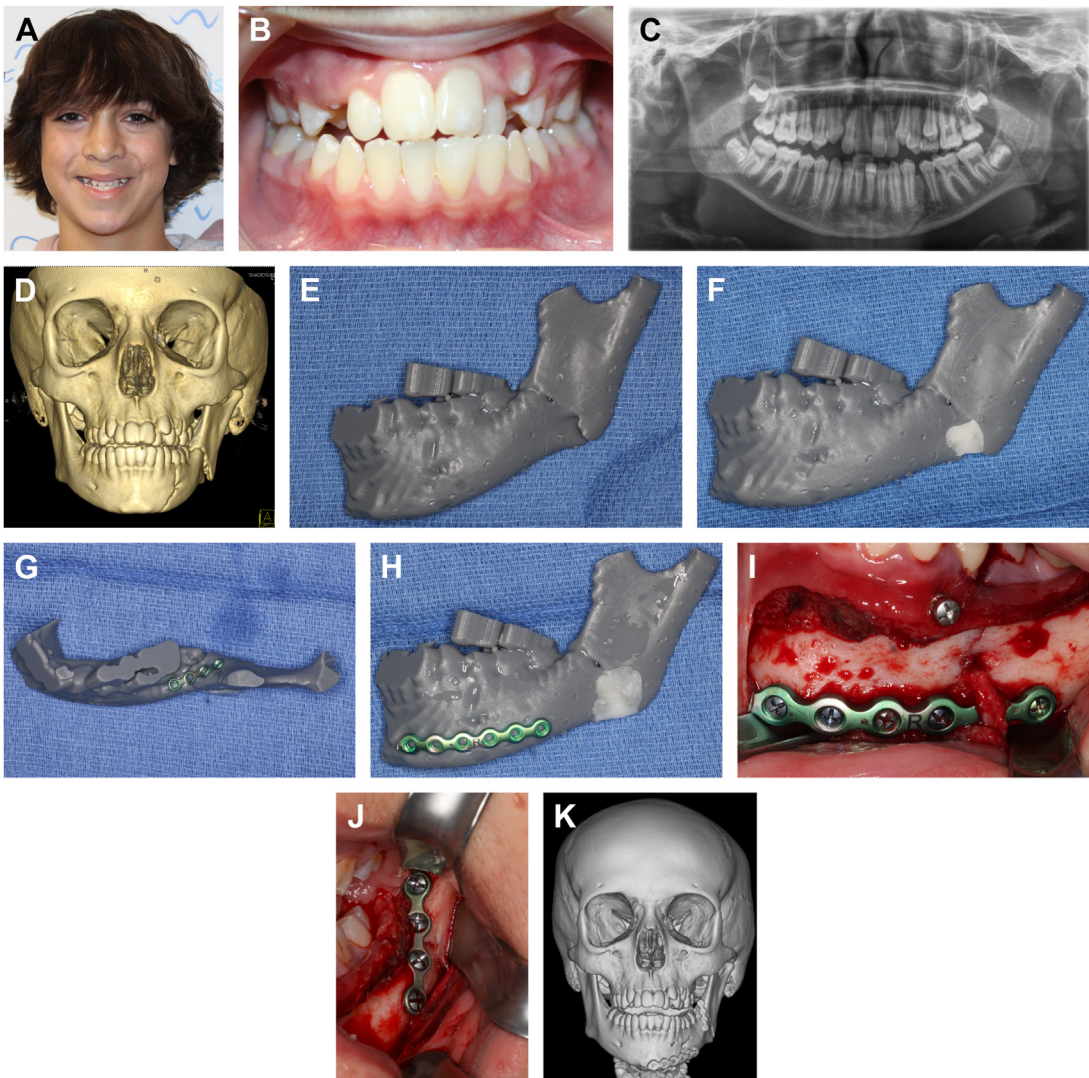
Case of a 12-year-old patient who sustained a hockey puck injury to the face resulting in left mandibular symphysis and angle fractures. (A, B) Preinjury patient records obtained from orthodontist demonstrating a baseline Class 3 malocclusion. Left-sided mandible fractures demonstrated on (C) panoramic and (D) CT images. (E) In-house point of care printing of the left hemimandible using CT data. (F) Fractured segments separated and anatomically reduced. (G, H) Titanium plates prebent and adapted to the perfected model. (I, J) Excellent intraoperative fit of prebent plates confirmed without the need for additional adjustment. (K) Final immediate post-operative result.
